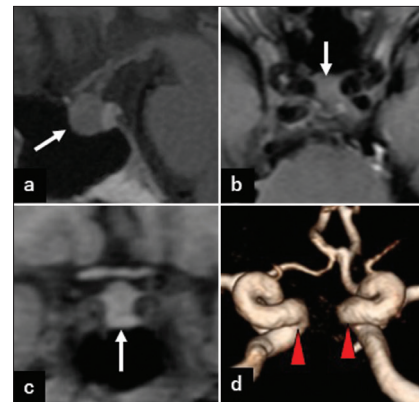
Magnetic resonance imaging of the pituitary mass at 77 years old. (a) T1-weighted (W) sagittal image. (b) T1W axial image. (c) T1W coronal image. (d) Three-dimensional reconstruction of time-of-flight magnetic resonance angiography. The size of the pituitary mass (arrow) did not change compared to 16 years before (a-c). Bilateral tortuous internal carotid arteries (red arrowheads) are running very near to each other (d).
